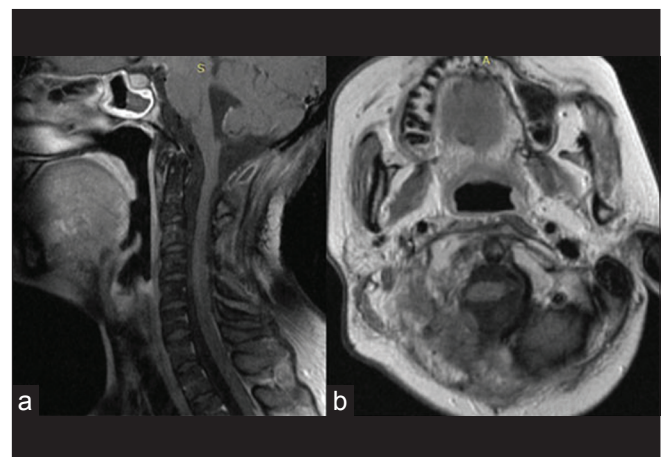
(a, b) Postgadolinium axial T1-weighted MRI scan showing no post-treatment tumor re-growth
